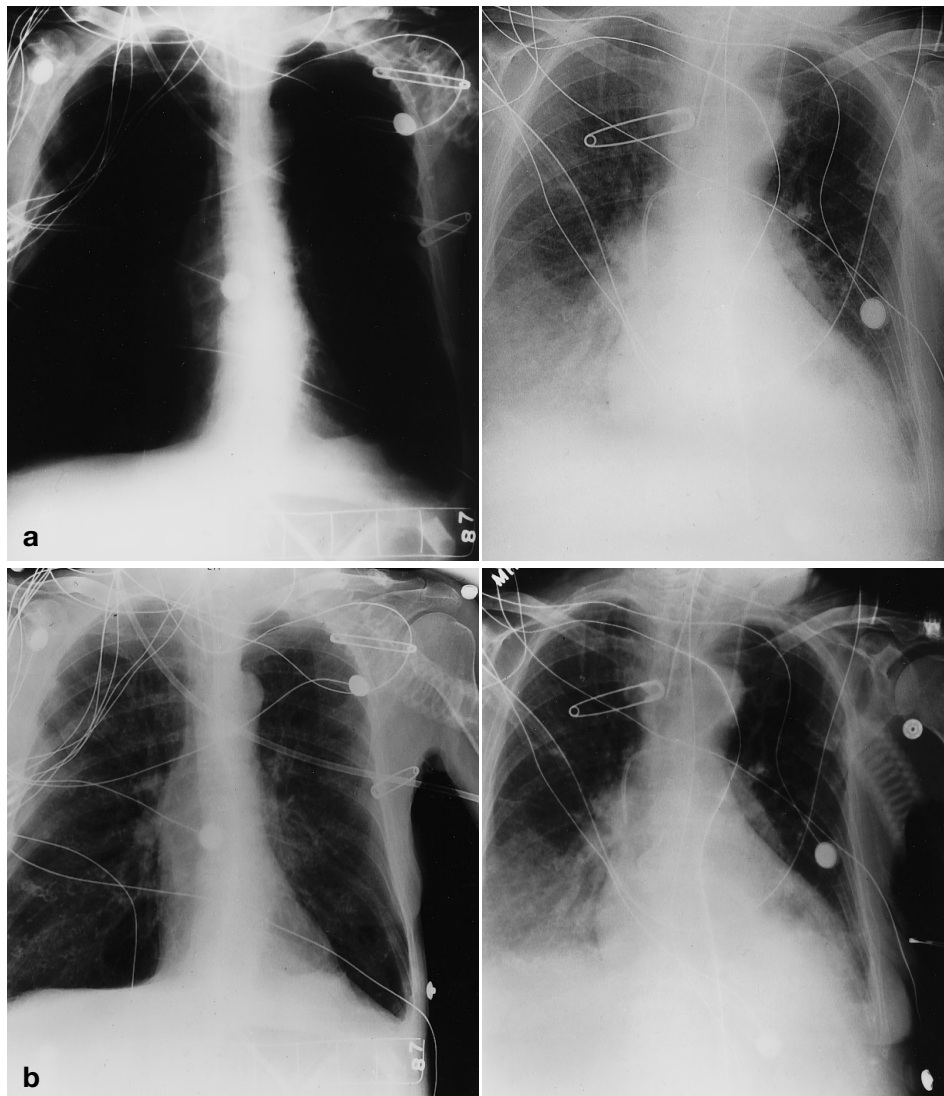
Conventional (a) and digital (b) follow up chest radiographs at the bedside. The first images were taken while the patient suffered from severe cardiac failure, the second image was obtained after therapy and improvement of clinical symptoms. The simultaneously obtained digital radiographs show more consistent and optimised image density compared to the digital radiographs
